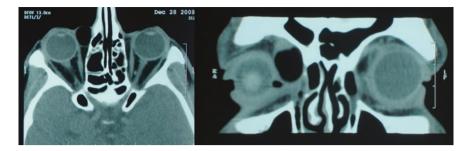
CT-scan showing medial canthal mass that is hypo-dense and appears like fat; characteristic of dermoid cyst
